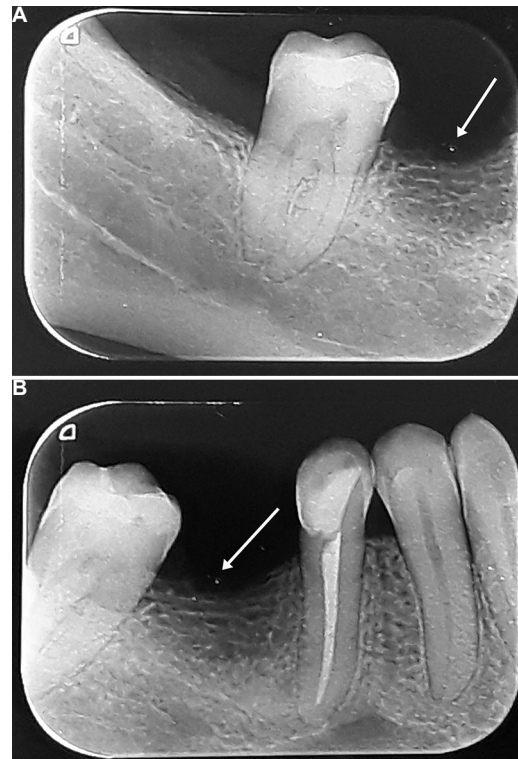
Periapical X-ray image. View of (A) second right lower molar, (B) region of first right lower molar. White arrows indicate a small particle with intense radiopacity.
